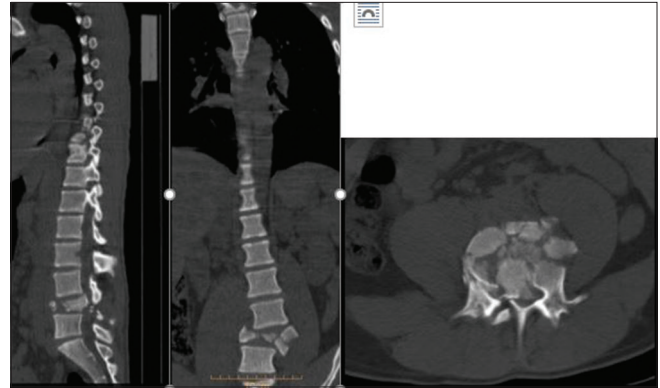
Sagittal, axial and coronal computed tomography scan revealed severe L4 burst fracture with completely canal compromise and posterior element involvement and decrease normal lumbar lordosis
